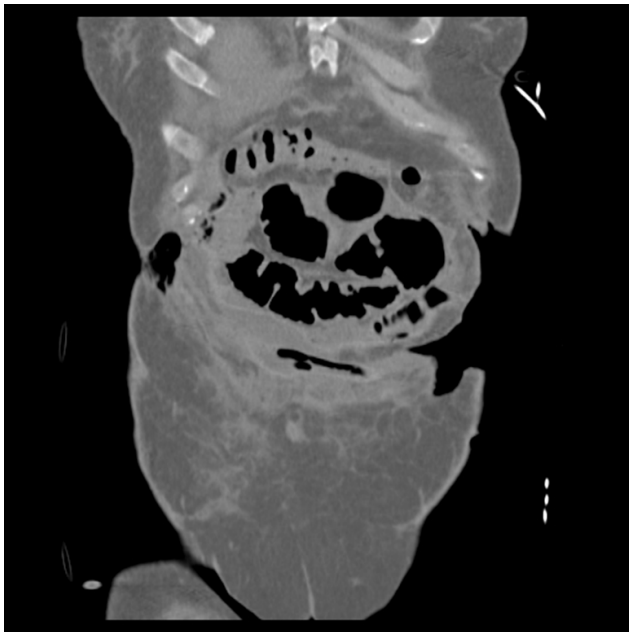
Frontal CT scan before the third intervention
